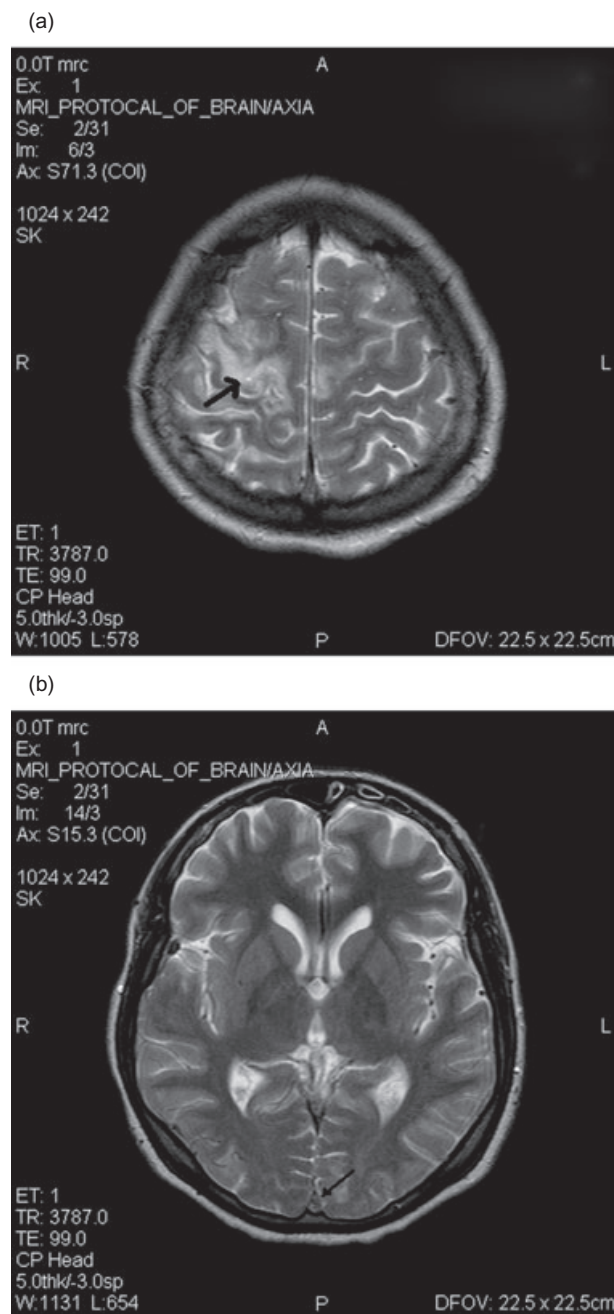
(a) Magnetic resonance image (MRI) shows bilateral high frontal brain edema, larger in the right side. (b) MRI shows mixed-staged thrombus in superior sagittal sinus.
